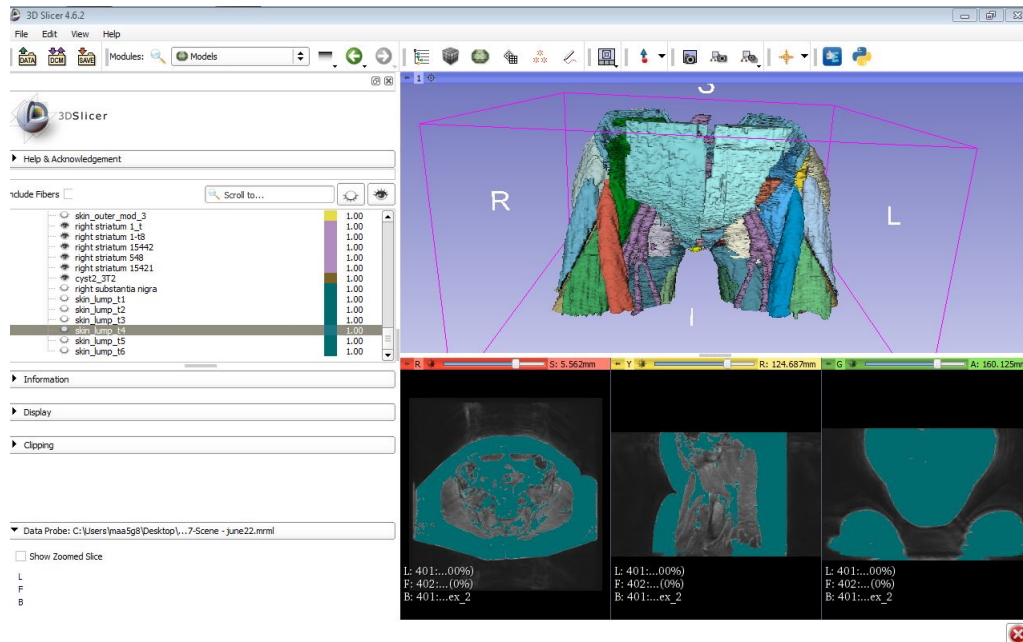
Pelvic MRI segmentation using 3D Slicer
